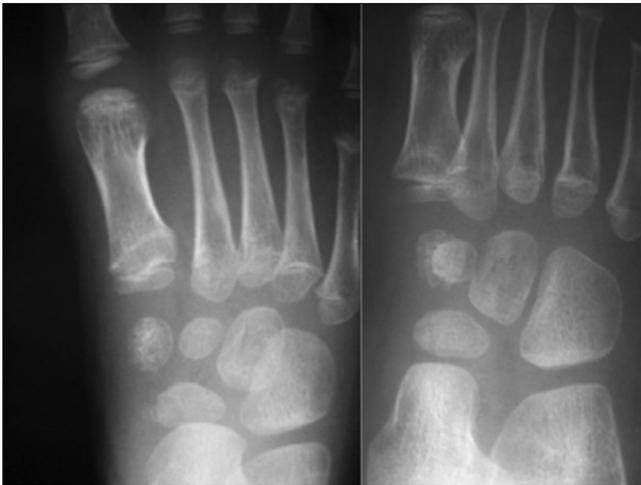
A 6-year-old boy with radiographic findings, consistent with osteochondrosis, involving the medial cuneiform bone
